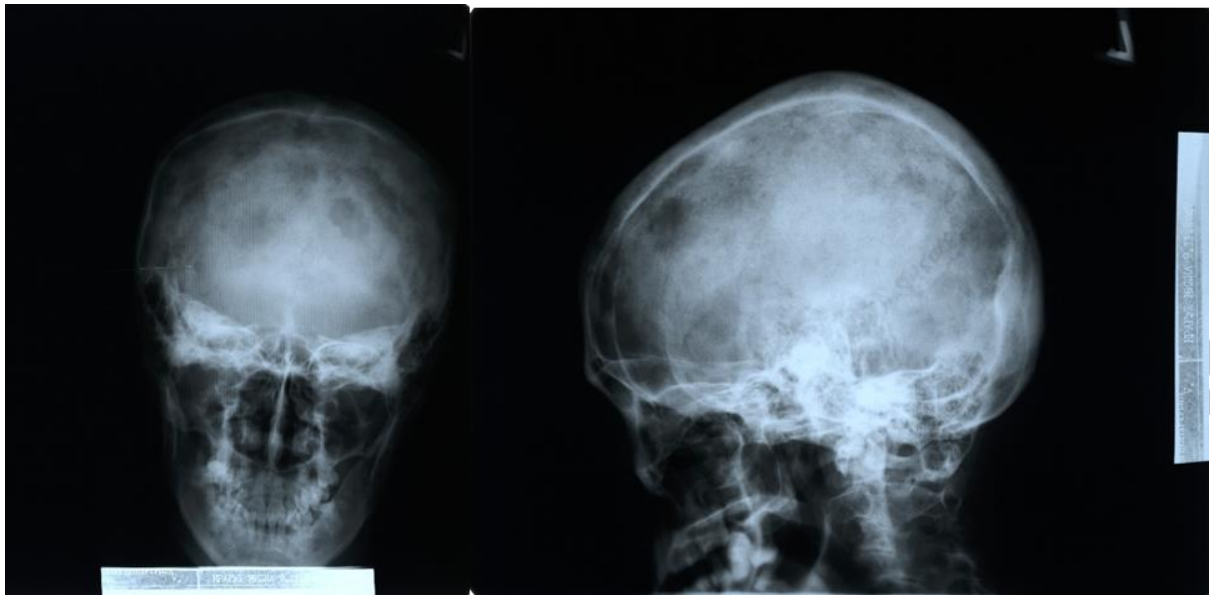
Radiography of the skull and spine with osteolytic metastasis
